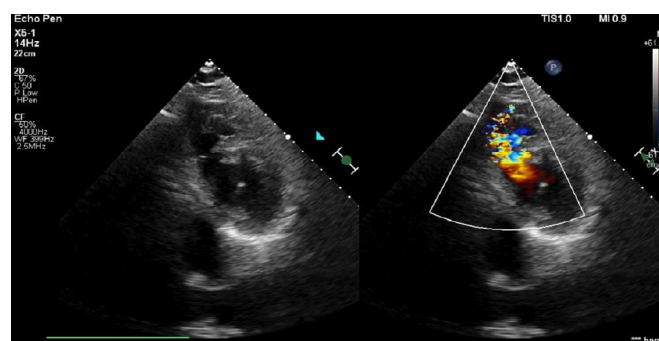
Transthoracic echocardiogram (short axis view) shows a large drop out of the interventricular septum with turbulent flow on colour Doppler representing the ventricular septal rupture (white arrow).
